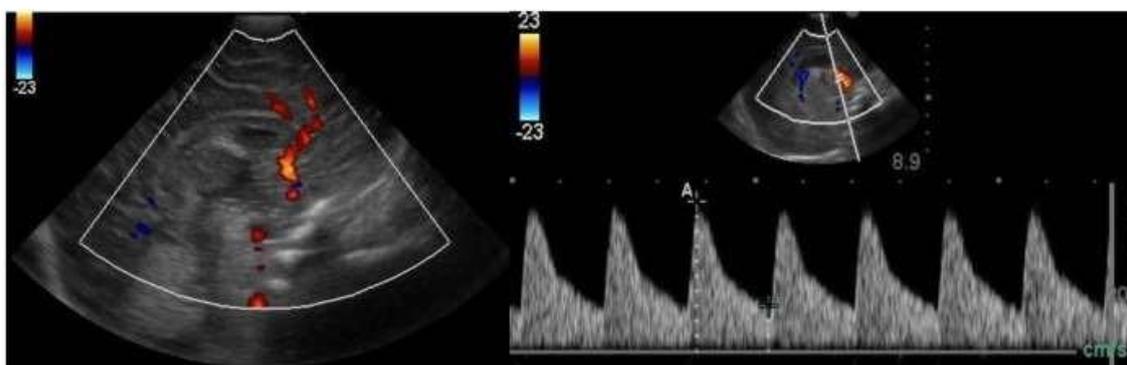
Follow up Doppler ACA.
